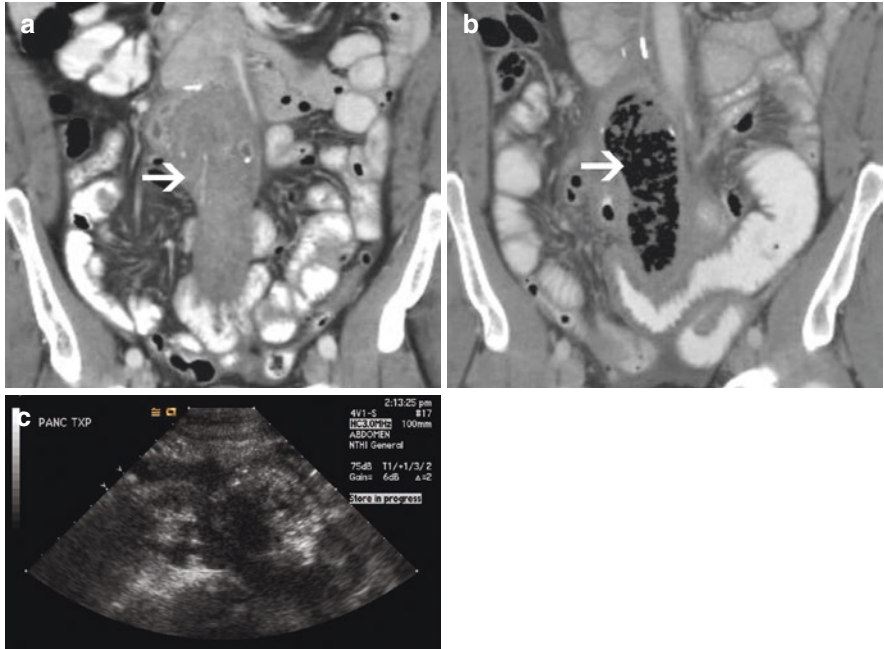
(a) Coronal CT image of the pancreas (arrow) showing diffuse edema of the graft parenchyma secondary to acute rejection. (b) Subsequent contrast-enhanced CT study in the same patient with acute rejection shows complete necrosis of the pancreas transplant. The necrotic cavity was filled with air (arrow)
